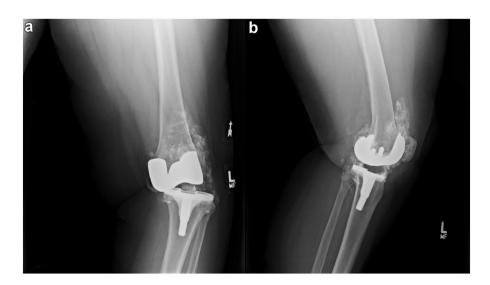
(a) Anteroposterior and (b) lateral x-rays of a skeletally mature left knee demonstrate metallosis and heterotopic ossification in the superior patellar pouch and the lateral gutter. The anteroposterior view shows complete medial compartment collapse, medial subluxation, and subsequent varus alignment. The femoral and tibial components were properly sized with no signs of loosening or fractures.
